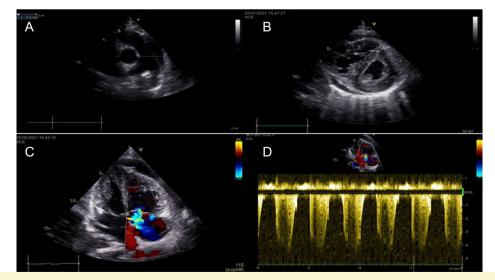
(A) Transthoracic echocardiography shows dilated pulmonary artery in parasternal short axis view. (B) Transthoracic echocardiography shows that the right ventricle is dilated and the interventricular septum is flattened, and the left ventricle takes a D shape in the parasternal short axis view. (C) In the apical 4-chamber view, dilated right ventricle and moderate tricuspid regurgitation with color Doppler and also pericardial effusion are seen. (D) Estimated systolic pulmonary artery pressure measured over the tricuspid regurgitation jet.
